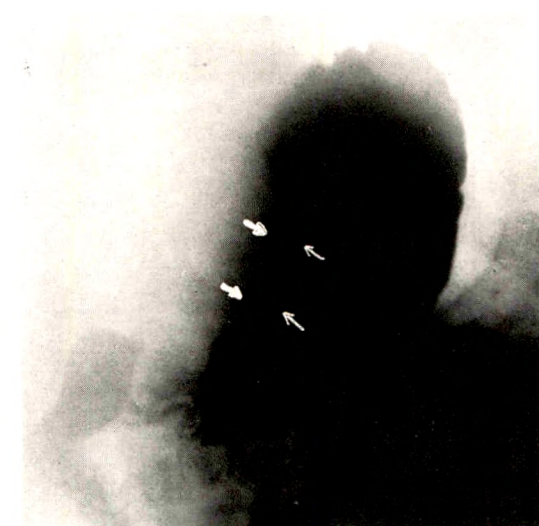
Case 1. Roentgenogram showing an extremely small stomach, with a fixed area on the lesser curvature.
